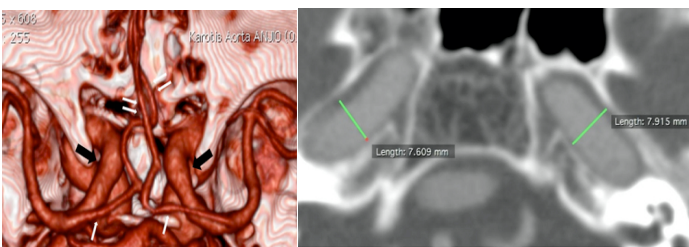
70-year-old woman with internal cerebral artery (ICA) and anterior cerebral artery (ACA) dolichoectasia. Volume rendering CT image (a) shows dolichoectasia both in ICA (wide black arrows) and ACA (narrow white arrows). On axial CT image (b) carotid canals are widened together with dolichoectasia.
